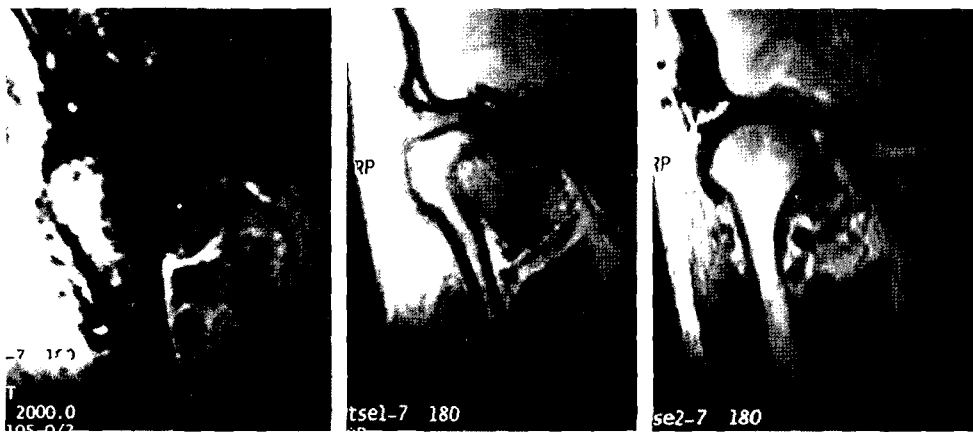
The coronal magnetic resonance images of temporomandibular joint. The disc appears to be in the central position (a), displaced medially (b), and displaced laterally (c).
